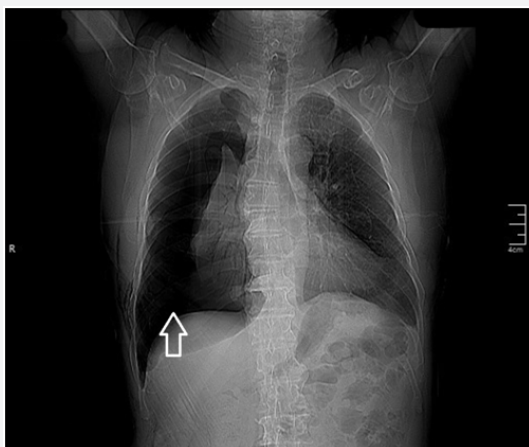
X-ray showing the fractures and right pneumothorax (arrow).
